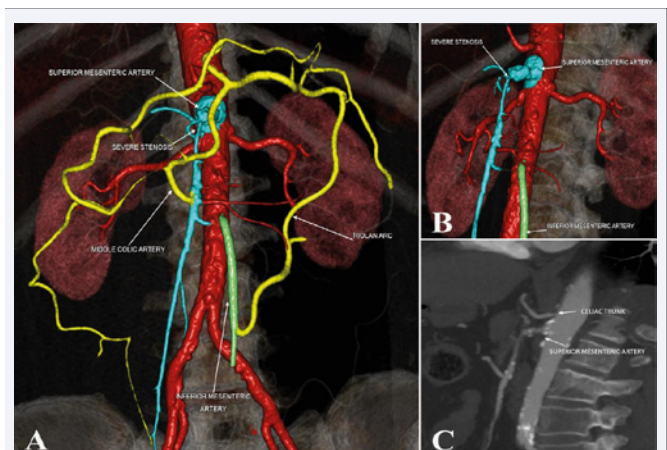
A: Computed tomography angiography (CT angiography) showing a nearly complete blockage of the superior mesenteric artery (SMA) and a collateral circulatory pathway via the inferior mesenteric artery.
